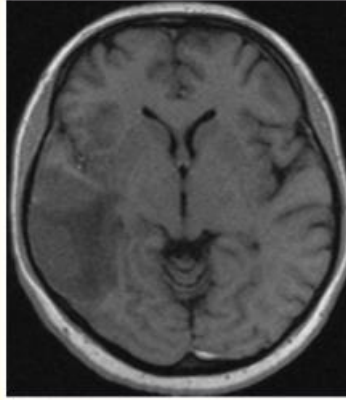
MRI with ischemic stroke in the left MCR basin (left hypodence zone).
